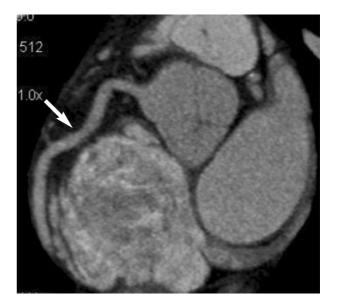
Coronarographic image obtained with a 64 row CT scan (MIP). Good visualization of right coronary artery (arrow).
